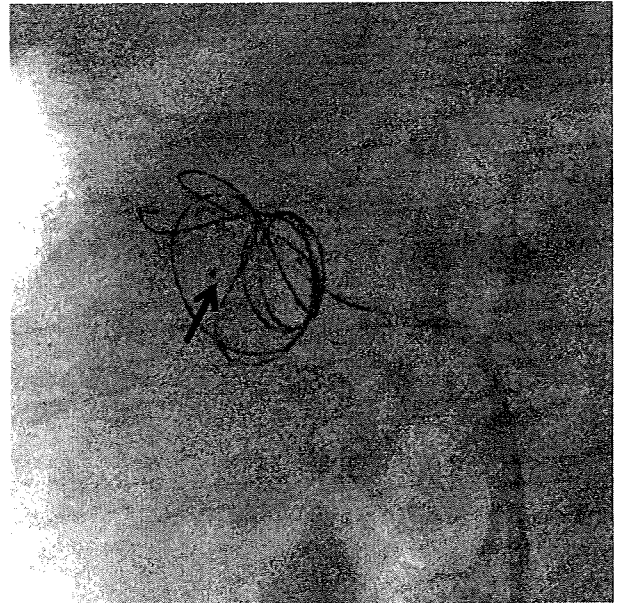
Intraoperative plain X-ray. Two microcatheters have been inserted to different locations in the aneurysm. Detachable coils are being inserted using one of the catheters, while the tip of the other microcatheter can be seen in the aneurysm (→).
